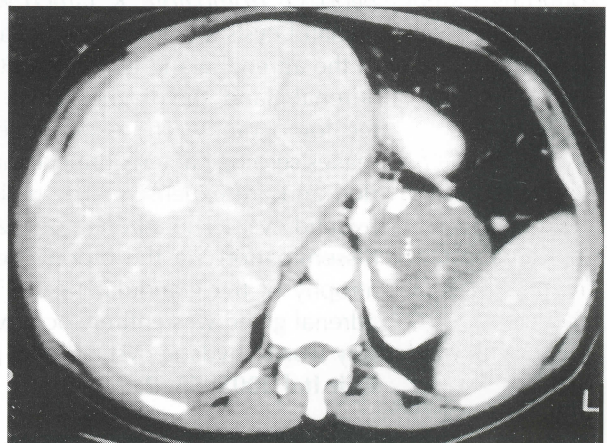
Computed tomography. The left adrenal gland is entirely replaced by a cystic lesion.
